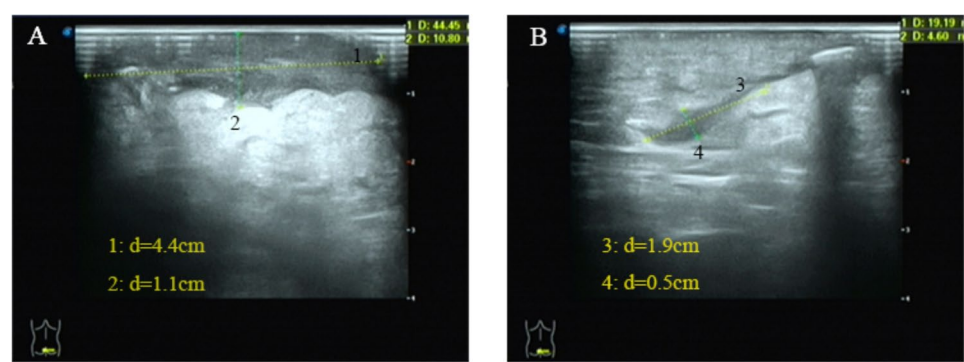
Ultrasonographic findings of the hepatocellular carcinoma patient. (A) Heterogeneous echoes with irregular morphology and indistinct margins were observed in the left perial region measuring approximately 4.4 × 1.1 cm. (B) Mixed echoes were identified within the deep adipose layer measuring around 1.9 × 0.5 cm
